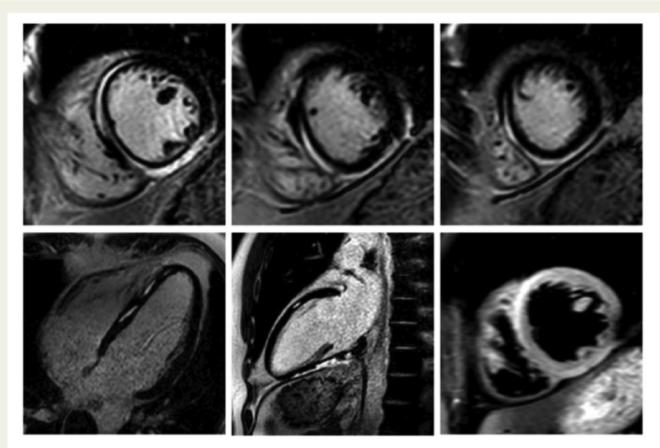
Cardiovascular magnetic resonance images at initial presentation showing marked mid- and epicardial hyper-enhancement in multiple segments on late gadolinium enhancement images and an area of myocardial oedema, in the anteroseptum on T2-weighted imaging. Top row (left to right): Basal short axis (SA), Mid-ventricular SA, Apical SA. Bottom row (left to right): four-chamber, two-chamber, T2-short tau inversion recovery (STIR) at mid-ventricular level.
